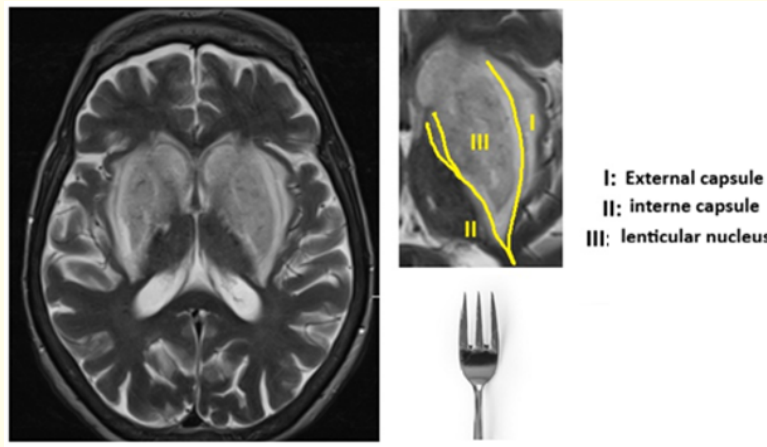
Axial T2-weighted MRI showing bilateral vasogenic edema surrounding the lentiform nuclei, outlining the characteristic "lentiform fork sign," composed of the lateral arm, stem, and medial arm.
